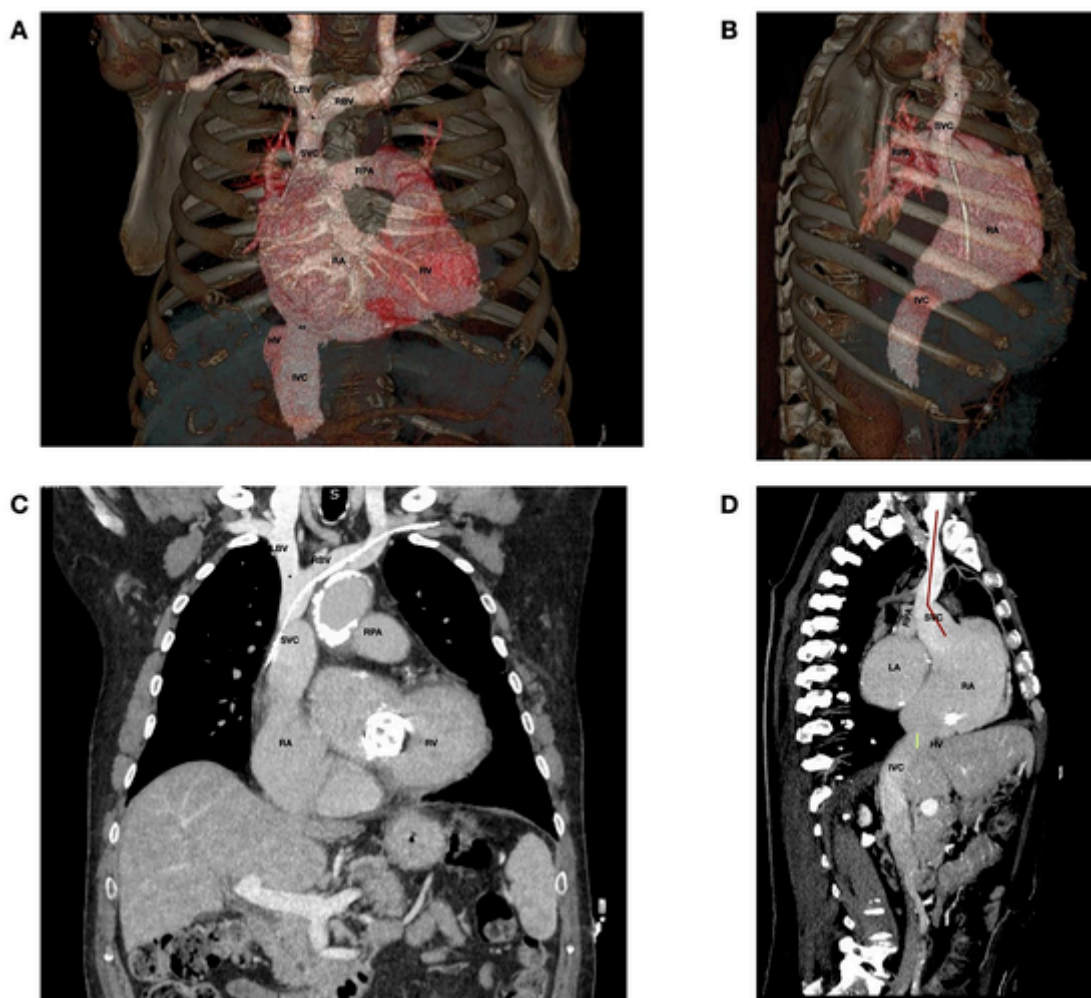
Venous CT reconstruction and main anatomical landmarks for pre-procedural planning.
